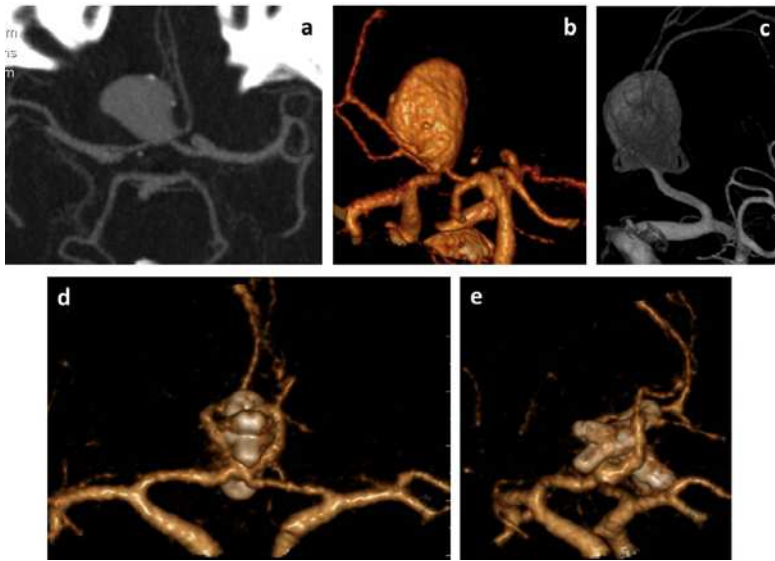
Pre-operative 3D-CTA and 3D-DSA showing a ruptured giant calcified and partially thrombosed ACom aneurysm (WFNS 2) (figures a-c). Treatment consisted of thrombectomy, endarterectomy and clip reconstruction. 3D-CTA performed 72 h after surgery documented aneurysm exclusion and patency of all the ACom complex arteries (figures d-e).
